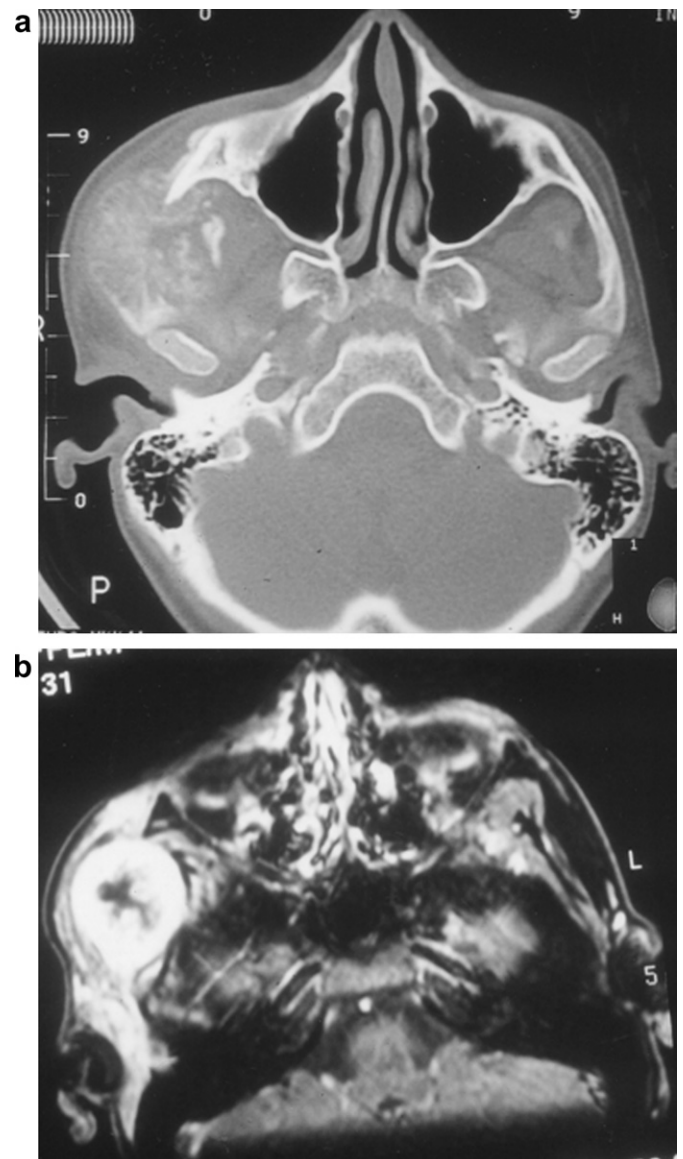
(a) Computed tomography of an osteosarcoma of the right zygomatic arch. (b) Magnetic resonance tomography (T1) of the same lesion.
